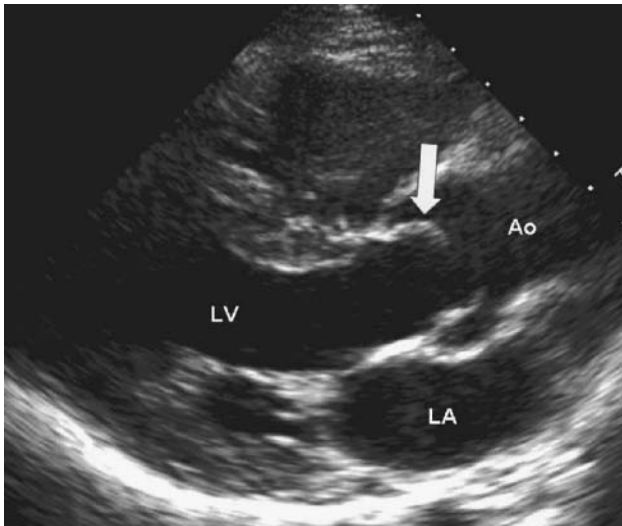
Parasternal long-axis transthoracic echocardiogram of a patient with a normally functioning bicuspid aortic valve (BAV). During systole, the valve leaflet opening is limited by the leaflet size, forming a doming of the leaflet and creating an audible systolic ejection click. This finding is very typical of a BAV. LV, left ventricle; LA, left atrium; Ao, aorta.
